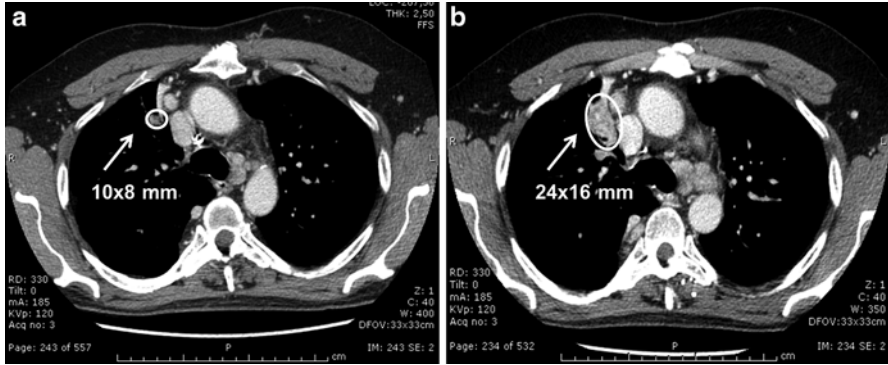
CT scan of the lung performed 6 months after the vandetanib treatment (Panel a) showed a significant reduction of the metastatic lesions and in particular of the lymph node of the hilum with respect to the CT scan performed before starting vandetanib (10 mm vs. 24 mm: -58%) (Panel b)
